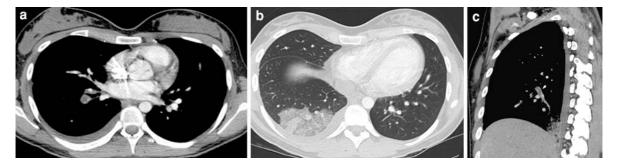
Pulmonary embolism in 19-year-old woman at 18 weeks gestation who presented with pleuritic chest pain (\mathbf{a} , \mathbf{b} , \mathbf{c}). CT pulmonary angiography images obtained with 100 kVp and max mA of 200 demonstrate acute thrombus within the right lower lobe posterior-basal segmental artery (\mathbf{a}) and peripheral
